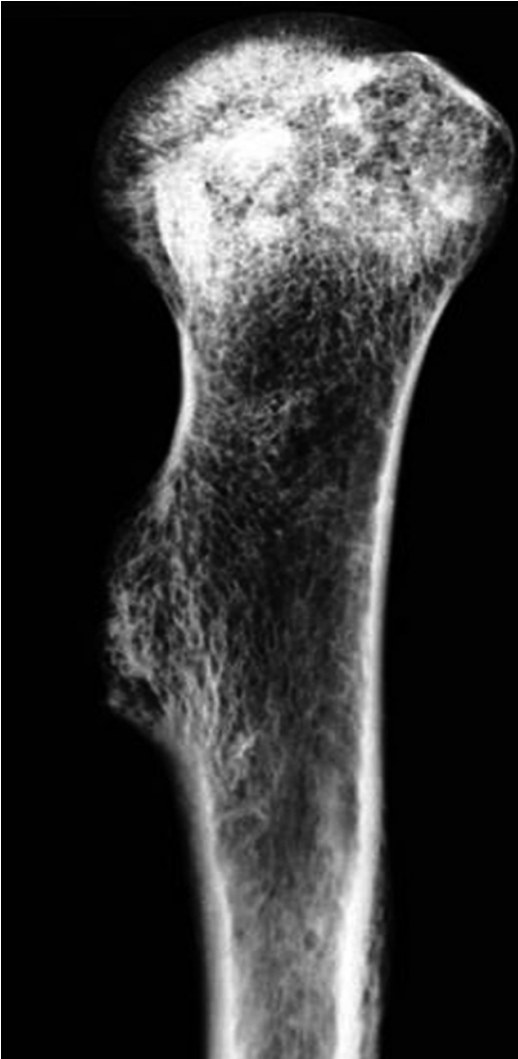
X-rays antero-posterior view of the proximal humerus. Exostotic lesion with no osteostructural alterations
